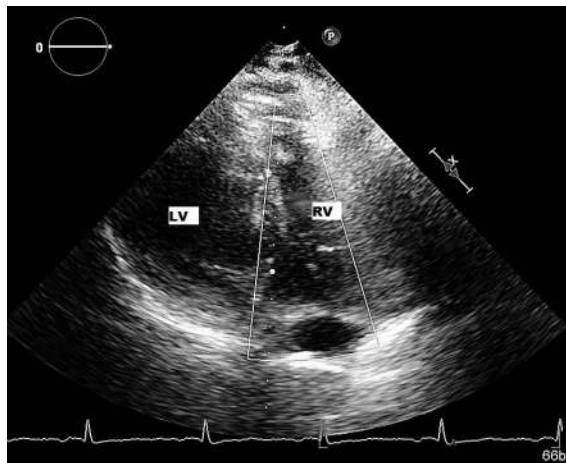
Echocardiography (taken in semi-orthostatic position): enlarged, hypokinetic left ventricle.
